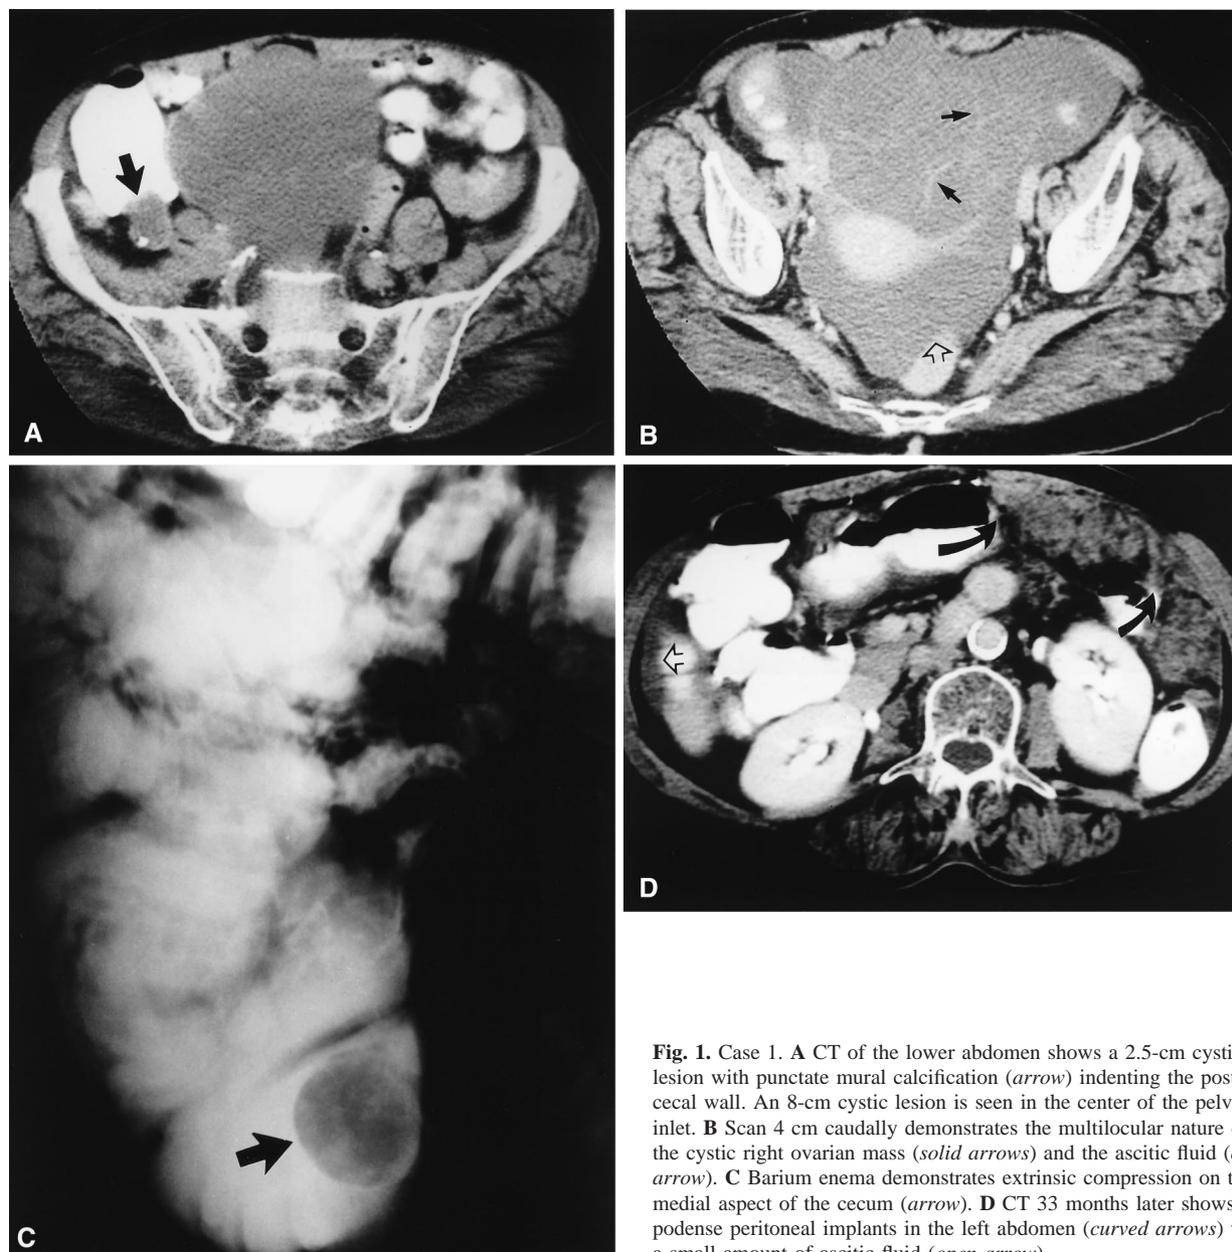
Case 1. A CT of the lower abdomen shows a 2.5-cm cystic lesion with punctate mural calcification (*arrow*) indenting the posterior cecal wall. An 8-cm cystic lesion is seen in the center of the pelvic inlet. B Scan 4 cm caudally demonstrates the multilocular nature of the cystic right ovarian mass (*solid arrows*) and the ascitic fluid (*open arrow*). C Barium enema demonstrates extrinsic compression on the medial aspect of the cecum (*arrow*). D CT 33 months later shows hypodense peritoneal implants in the left abdomen (*curved arrows*) with a small amount of ascitic fluid (*open arrow*).
